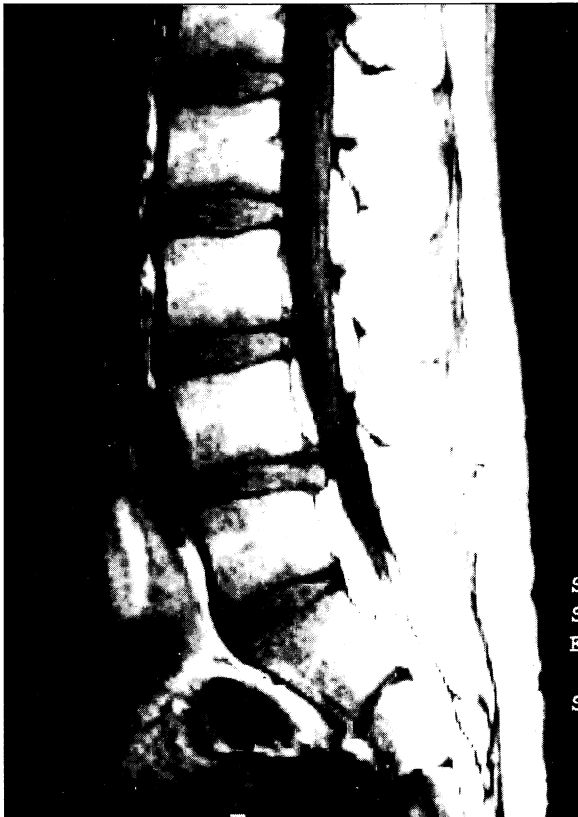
Sagittal T1-weighted image showing a soft tissue lesion impinging the thecal sac at L4/L5
